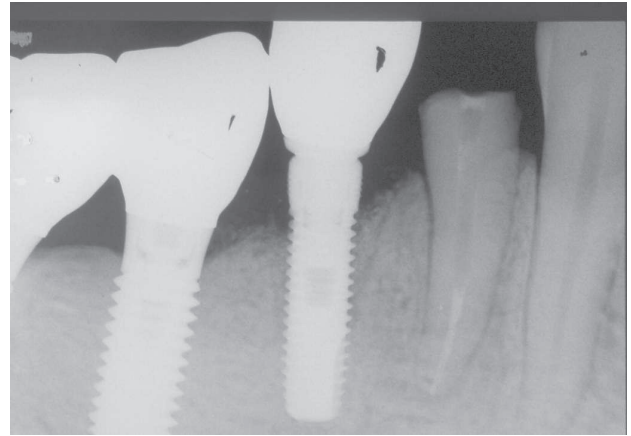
Radiograph taken at the time of delivery of prosthesis, which was 4 months after treatment. The crown of the lower right first premolar was removed because the tooth was under preparation for restoration.
